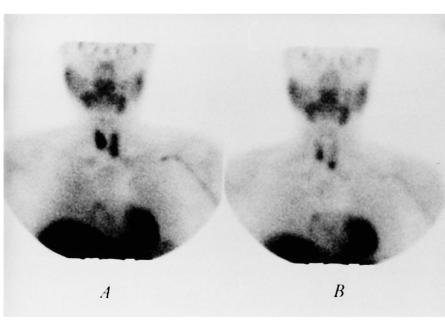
^{99m}Tc-sestamibi parathyroid imaging obtained at 15 min (A) and 2 h (B) post injection. On delayed imaging there are two focal areas of increased activity in both lower poles of the thyroid (which were scored as moderate uptake). During surgery, three hyperplastic glands (weighing 1500, 950 and 240 mg) were found. The gland weighing 240 mg was not seen on scintigraphy and was situated in the upper left pole of the thyroid
